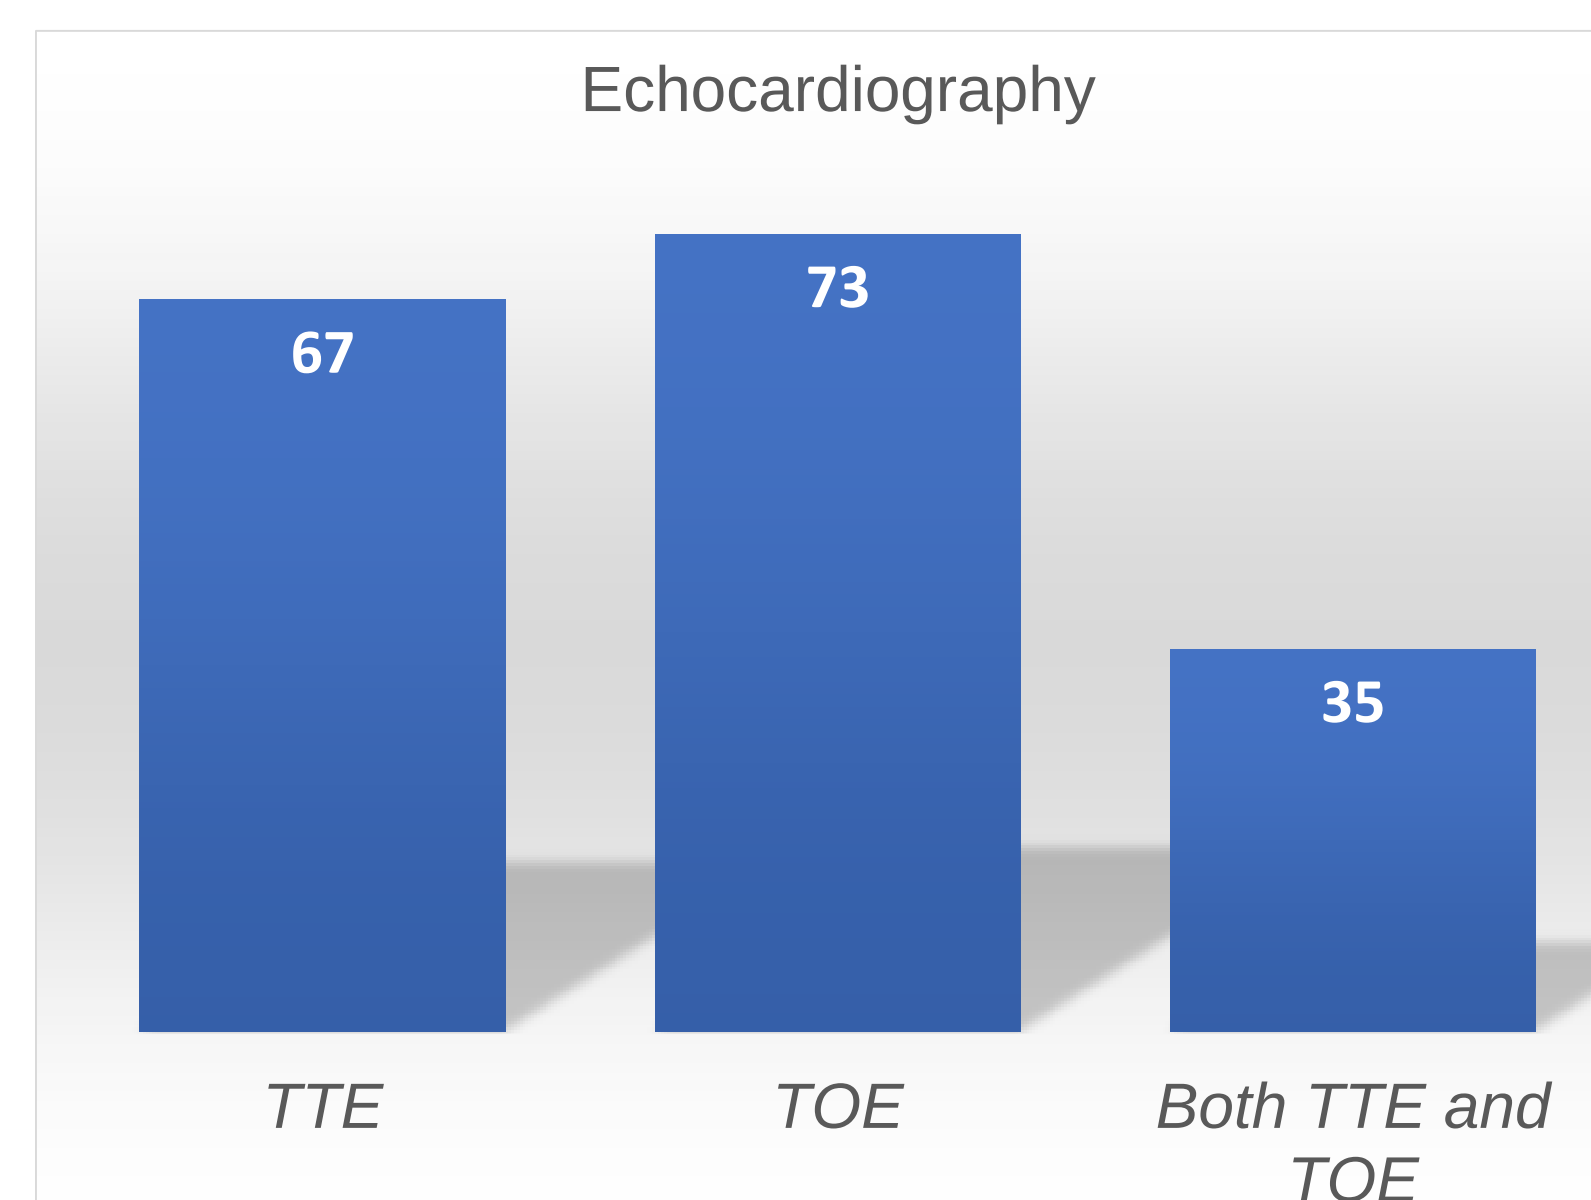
Echocardiography in the assessment and subsequent management in patients with suspected IE.
